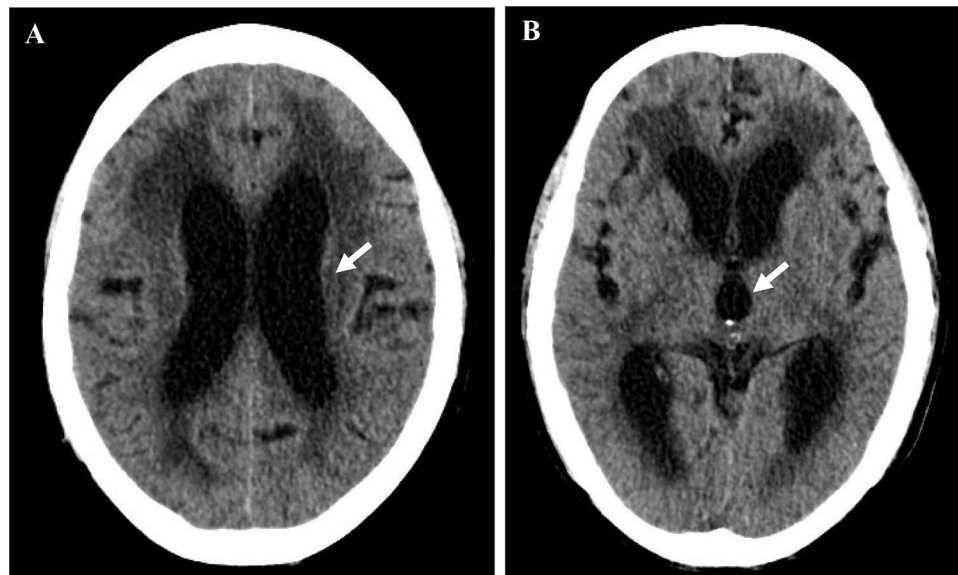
Brain CT scans depicting hydrocephalus. (A) Exhibited a dilated lateral ventricle (arrow). (B) Showed an expanded 3rd ventricle (arrow).
